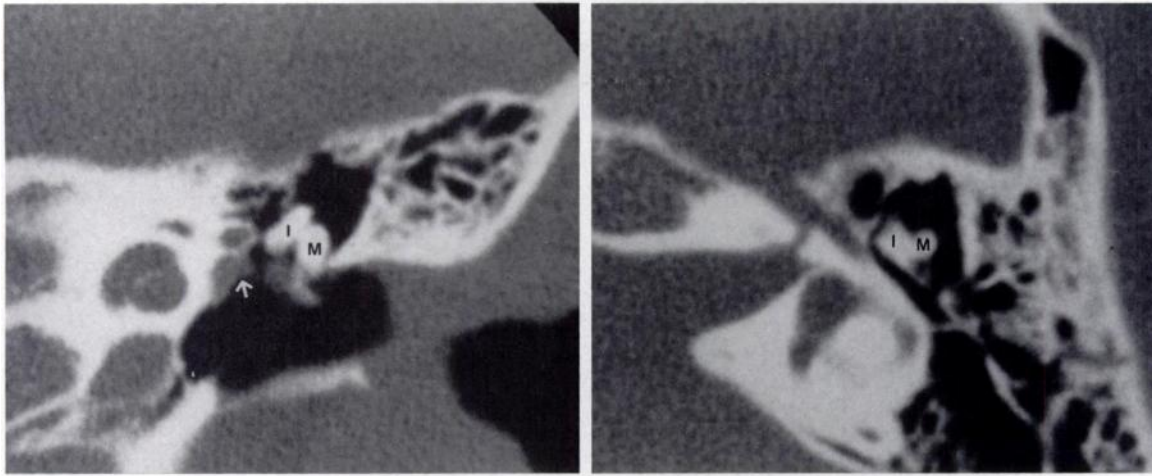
Incudomalleolar disarticulation. Axial CT scan of the left ear shows the body of the incus and its articulating surface (*a*) pulled away laterally from the head of the malleus (*b*).
